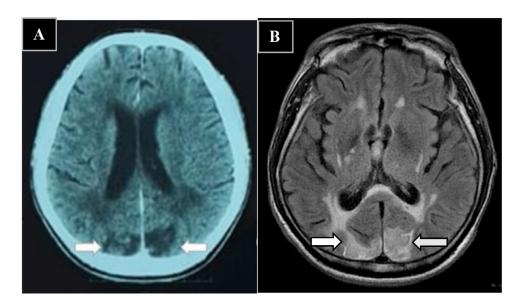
(A) Head CT scan without contrast showed bilateral occipital cerebral infarction. (B) Head MRI Fluid attenuated inversion recovery (FLAIR) sequence showed subacute ischemic cerebral infarction in the right and left cerebellar hemispheres, multiple lesions in the periventricular white matter, basal ganglia, right and left thalamus, and pons contribute to the appearance of Binswanger disease. CT, computed tomography.
